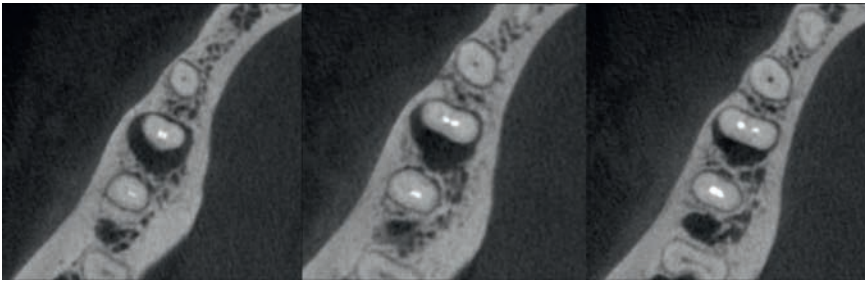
CBCT axial images.
